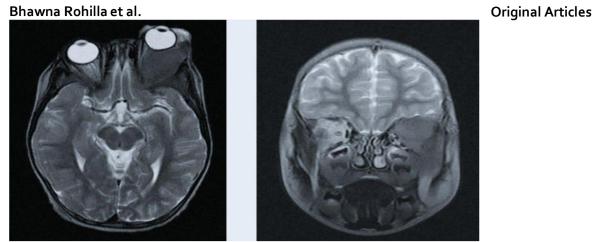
Showing MR images of a case with lymphomas
